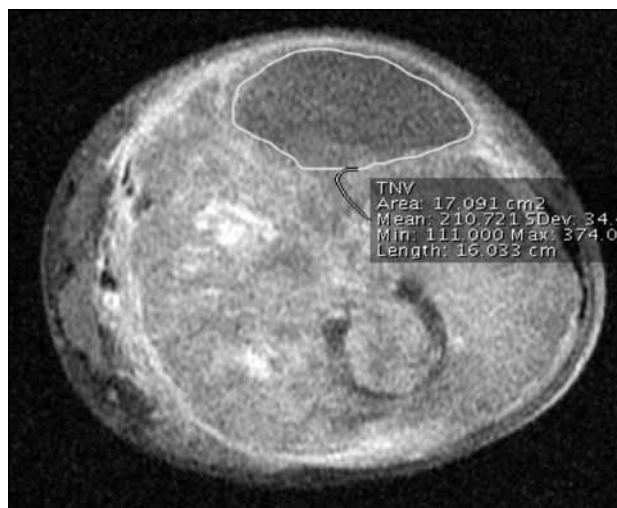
In this image, tumour necrotic area is shown as non-enhanced area within the tumour in post-contrast magnetic resonance imaging. Tumour necrotic area for this patient is 17.091 cm².
